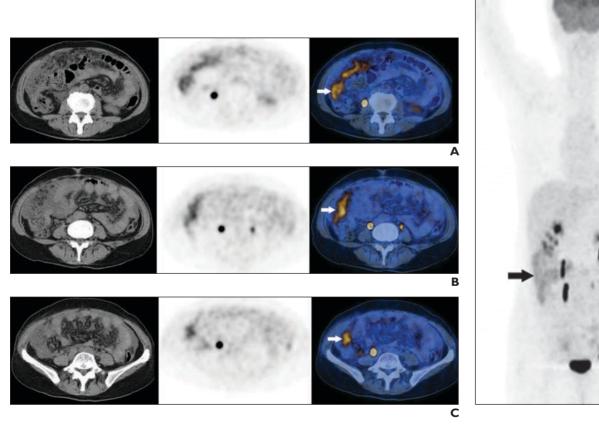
63-year-old woman with ascites and abdominal pain. Diagnosis based on ¹⁸F-FDG PET/CT examination was malignant disease. Pathologic diagnosis was moderately differentiated peritoneal cancer. Patient received chemotherapy for 3 months and died 8 months after undergoing FDG PET/CT examination.
